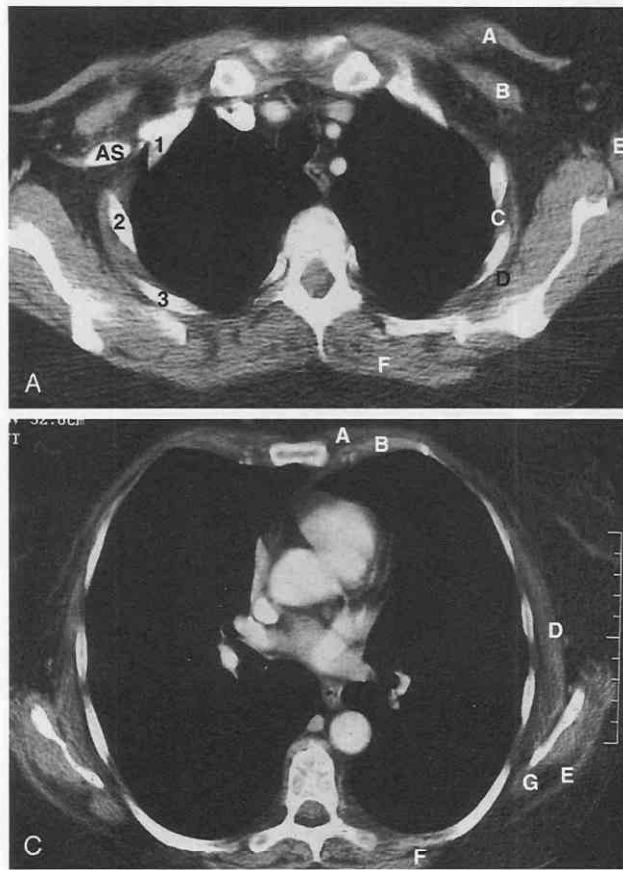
CT anatomy of the chest wall. *A*, Counting ribs one through three, the first rib is identified on the image, which shows the medial third of the clavicle. The second and third ribs are seen posteriorly along the rib cage. The axillary sheath contains the brachial plexus branches, and the axillary artery and vein. *B*, Sternal angle (SA) is shown as a high-attenuation structure connected laterally to the second costal cartilages and ribs. The third through sixth ribs are seen on the same slice counting posteriorly. *C*, Chest wall musculature is identified at an inferior level. *A*, pectoralis major; *AS*, axillary sheath; *B*, pectoralis minor; *C*, internal and external intercostal muscles; *D*, serratus anterior; *E*, latissimus dorsi; *F*, trapezius; *G*, rhomboid.
